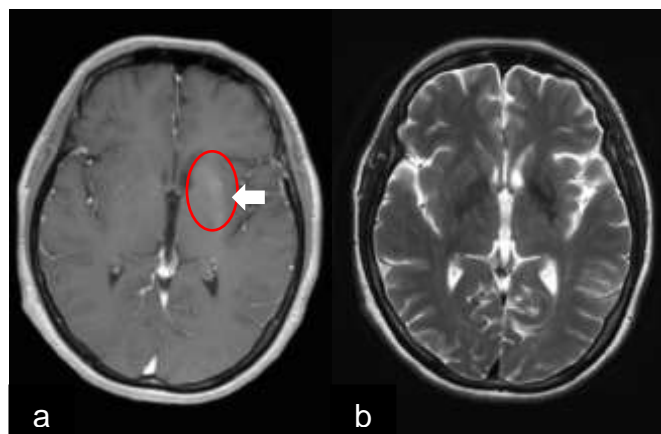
Head MRI without Contras (a. Sequence T1 hyperintensity in the left striatal; b. Sequence T2)
